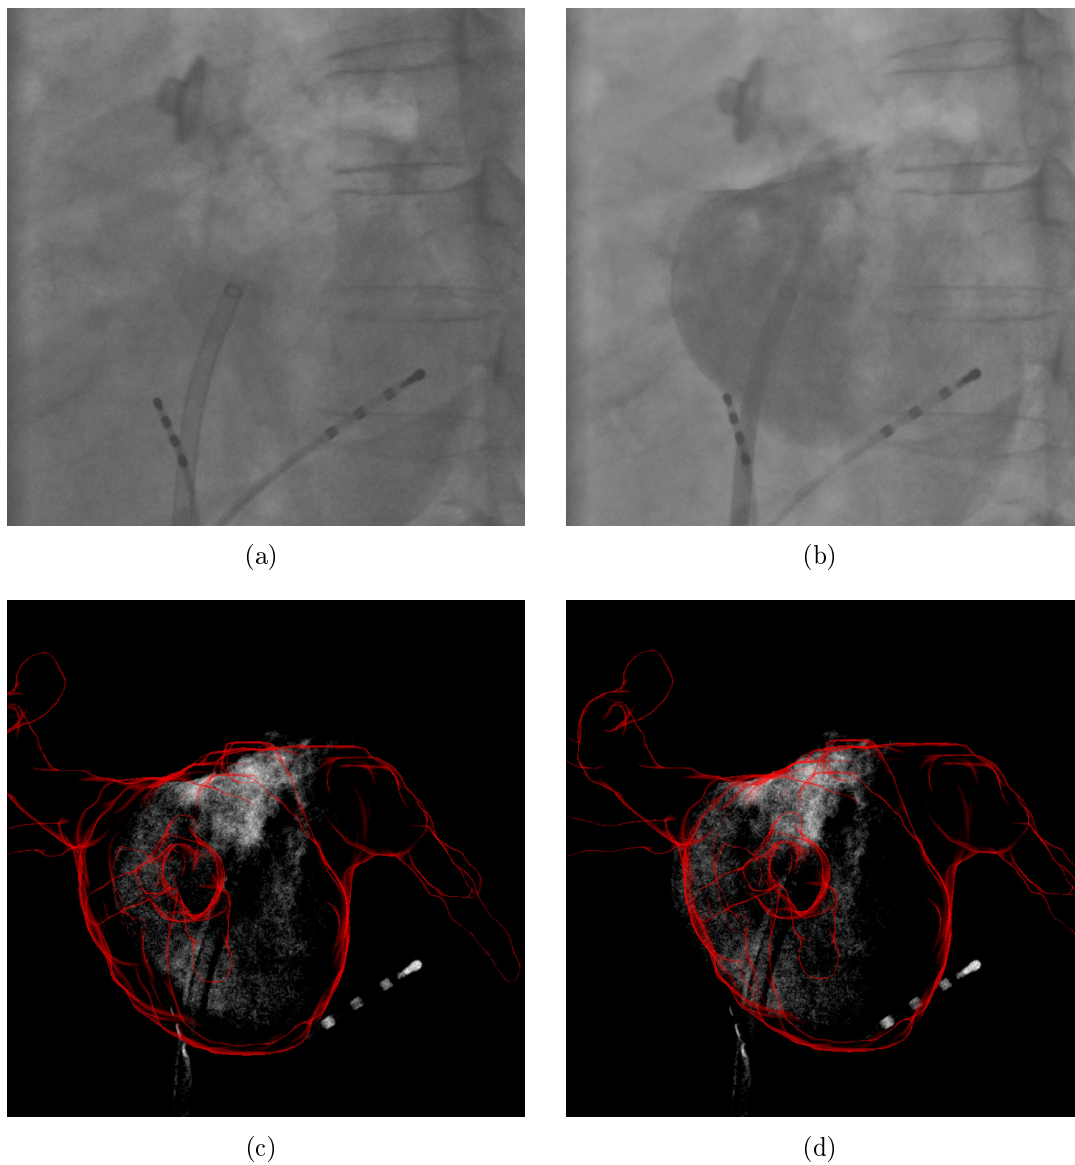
Uncontrasted (a) and contrasted (b) frame of an X-ray angiography. The registration result when using ρ_{shad}^{DSA} (c) had an error of 6.7 mm. By using $\rho_{CADE} + \rho_{edge}$ (d), the left border of the LA model fits better to the left edge of the CA and the error reduced to 3.1 mm
